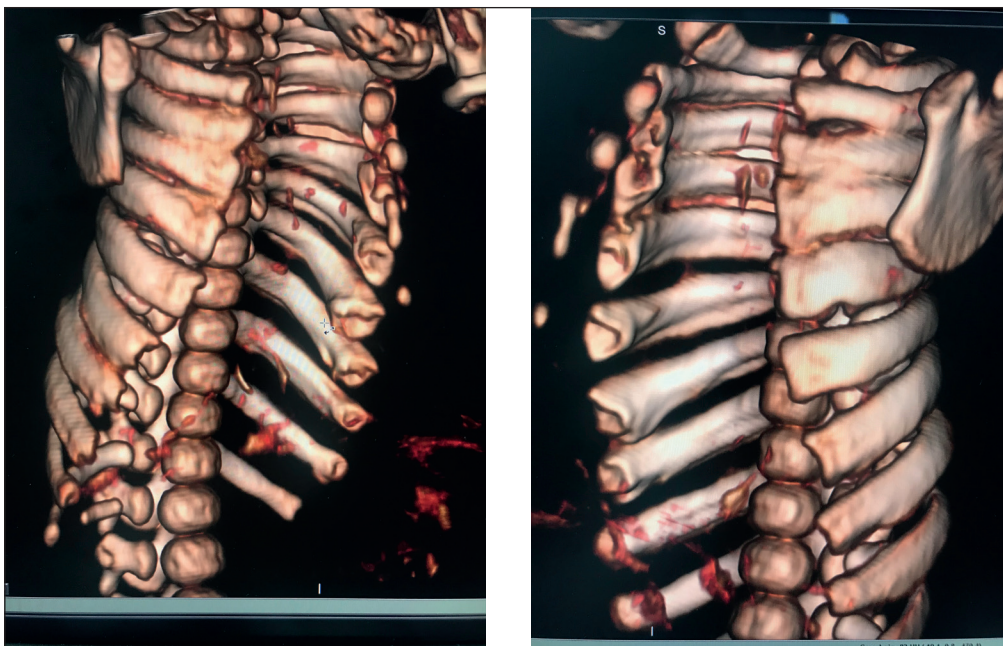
CT of the patient's chest with 3D-reconstruction performed at the age of 25 days: narrowed chest, wide, short, horizontally placed ribs with the fusion of II-Vth ribs in the anterior divisions.
